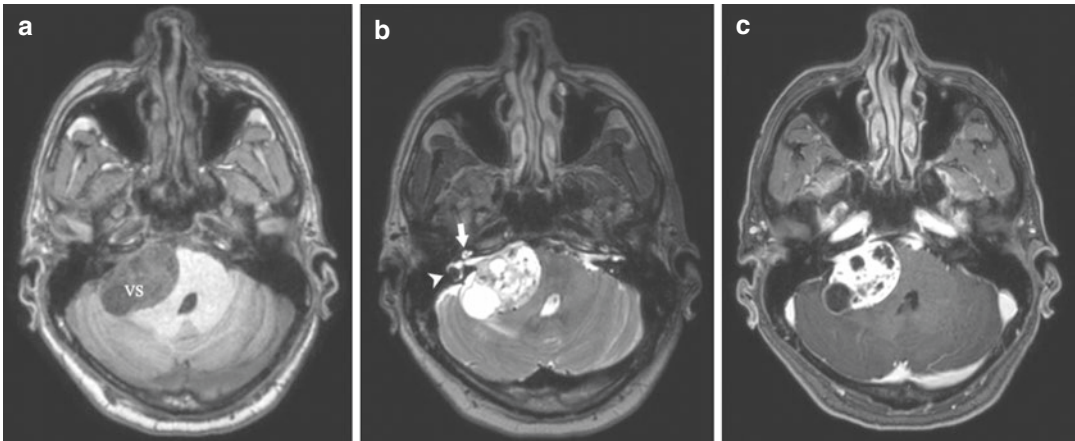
Vestibular schwannoma MRI, (a) T1-weighted, vestibular schwannoma (VS), (b) T2-weighted, cochlea (arrow), lateral semicircular canal (arrowhead), (c) T1 post gadolinium
